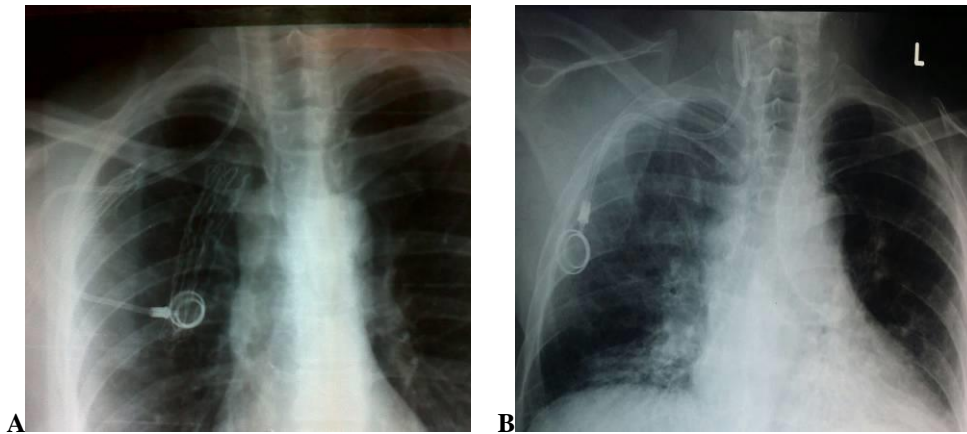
(A) plain x-ray showing misplaced porta A cath in right IJV;
